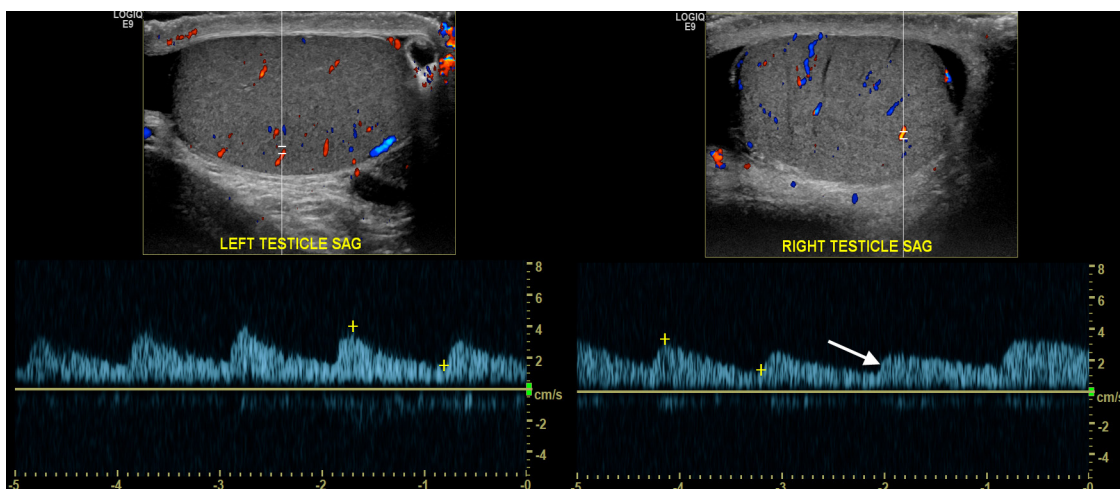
Transverse ultrasound image of the left testicle obtained with a 15Mhz linear-array transducer using spectral Doppler demonstrates normal arterial wave form and flow (2A). Spectral Doppler of the right testicle (white arrow) demonstrates comparatively decreased systolic velocities with slowing of the upstroke (2B).
